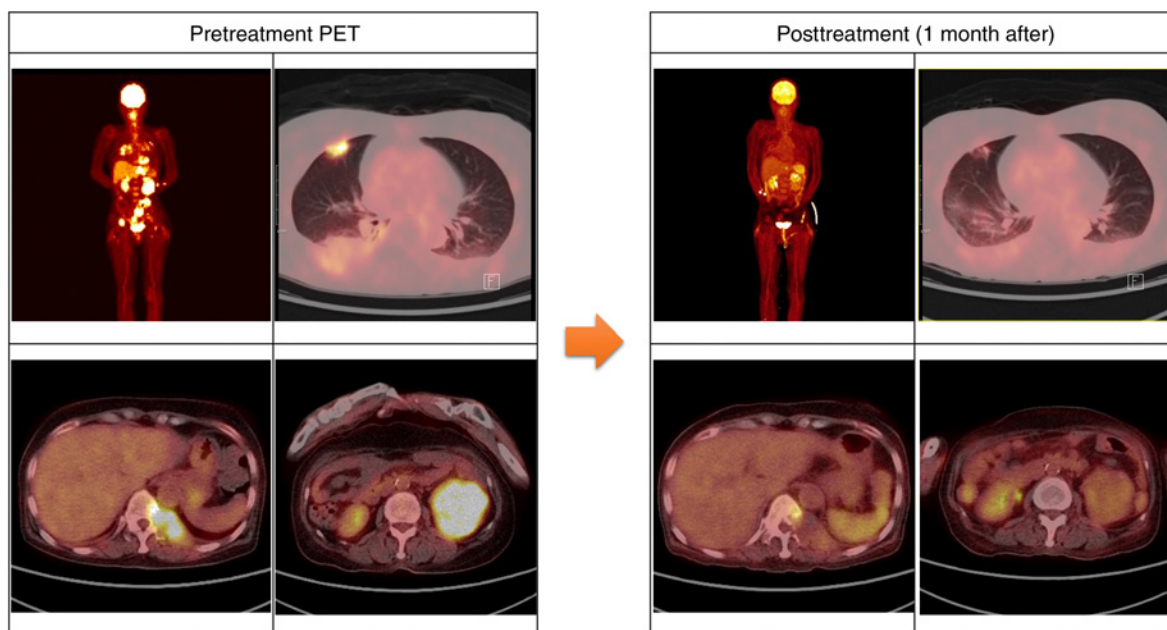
Metabolic response observed from PET images in Patient 5 who harbored NRAS Q61K mutation and received RAF inhibitor. The left panel shows pretreatment PET images: whole-body image in the left-upper, right middle lobe mass (SUV 9.3) in the right-upper, thoracic spine mass (SUV 13.3) in the left-lower, and left kidney mass (SUV 13.0) in the right-lower. The right panel shows PET images taken 1 month after treatment with RAF inhibitor: whole-body image in the left-upper, right middle lobe mass (SUV 2.0) in the right-upper, thoracic spine mass (SUV 2.8) in the left-lower, and left kidney mass (SUV 4.0) in the right lower. SUV, standardized uptake value.
